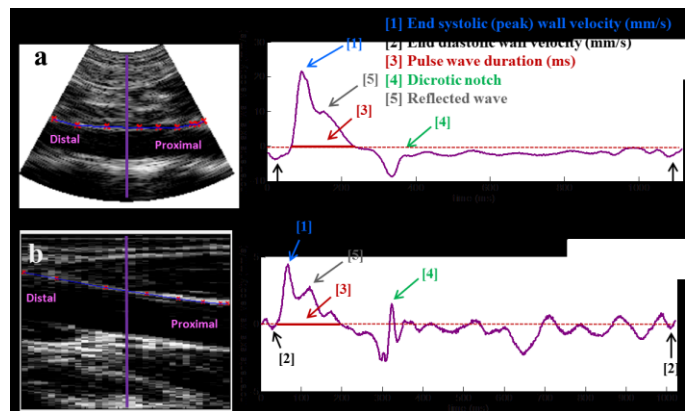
Pulse waveform obtained over one complete cardiac cycle from a single ultrasound beam line (shown in purple in the B-Mode field of view) in the anterior wall of the aorta (a) and carotid artery (b) of the same healthy volunteer.
